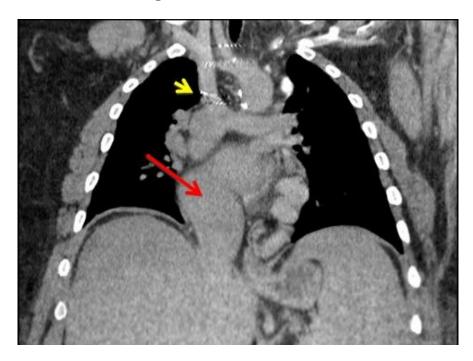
Thoracic CT scan showing Fontan anatomy with the superior vena cava (SVC) connected to the pulmonary arteries (yellow arrow) and a single atrium and ventricle (red arrow).
